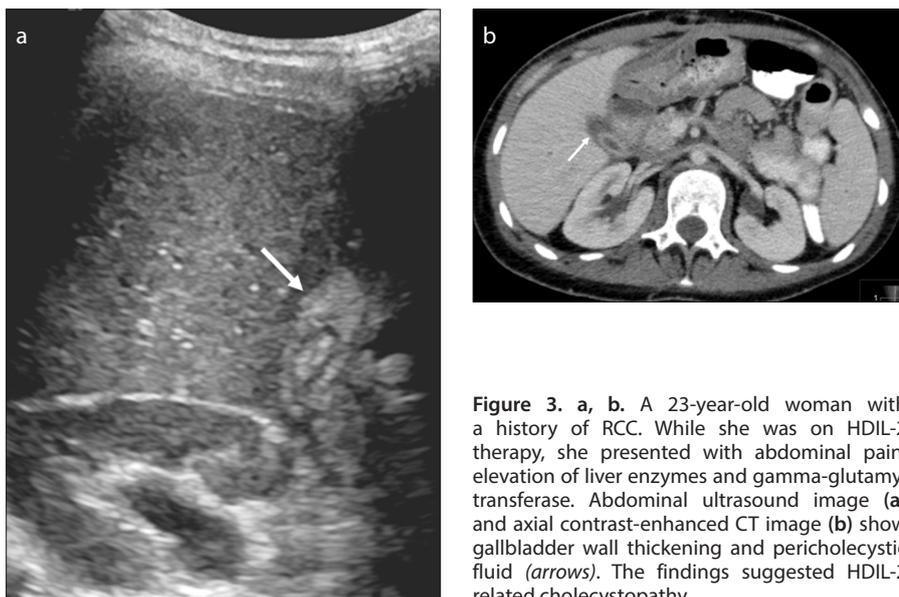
a, b. A 23-year-old woman with a history of RCC. While she was on HDIL-2 therapy, she presented with abdominal pain, elevation of liver enzymes and gamma-glutamyl transferase. Abdominal ultrasound image (a) and axial contrast-enhanced CT image (b) show gallbladder wall thickening and pericholecystic fluid (*arrows*). The findings suggested HDIL-2 related cholecystopathy.
